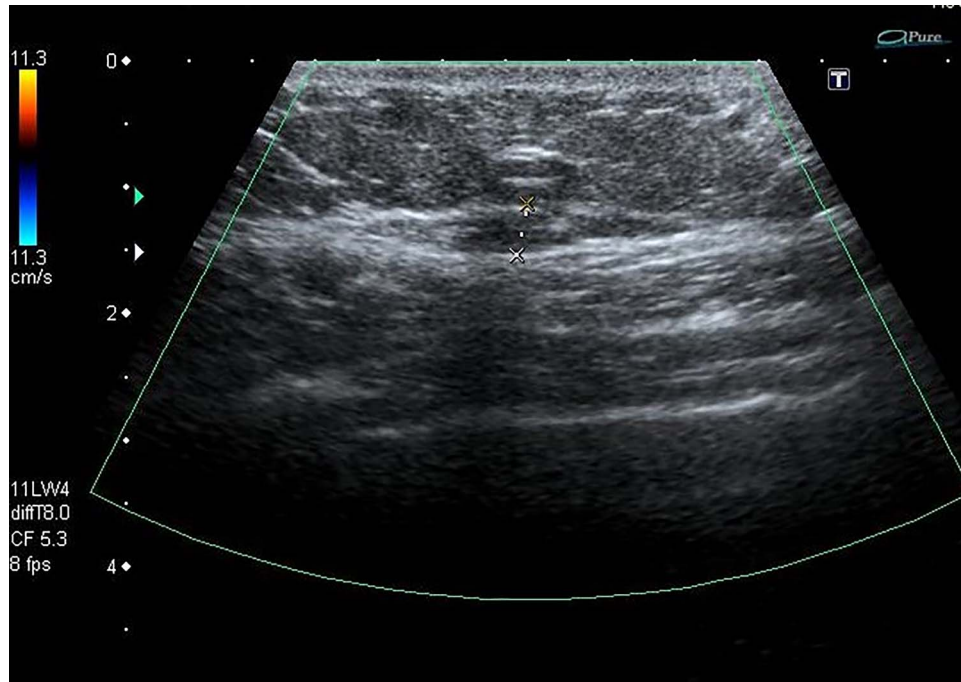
Duplex ultrasound: thrombosed right-sided superficial thoracic vein (longitudinal view).
